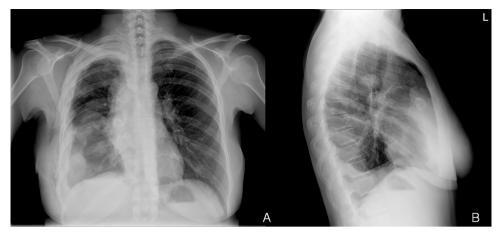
Chest X-ray, on posterior-anterior (A) and lateral (B) views, demonstrates hilar-mediastinal enlargement with multiple nodular radiopacities in right hemithorax and pleural effusion on the same side.
